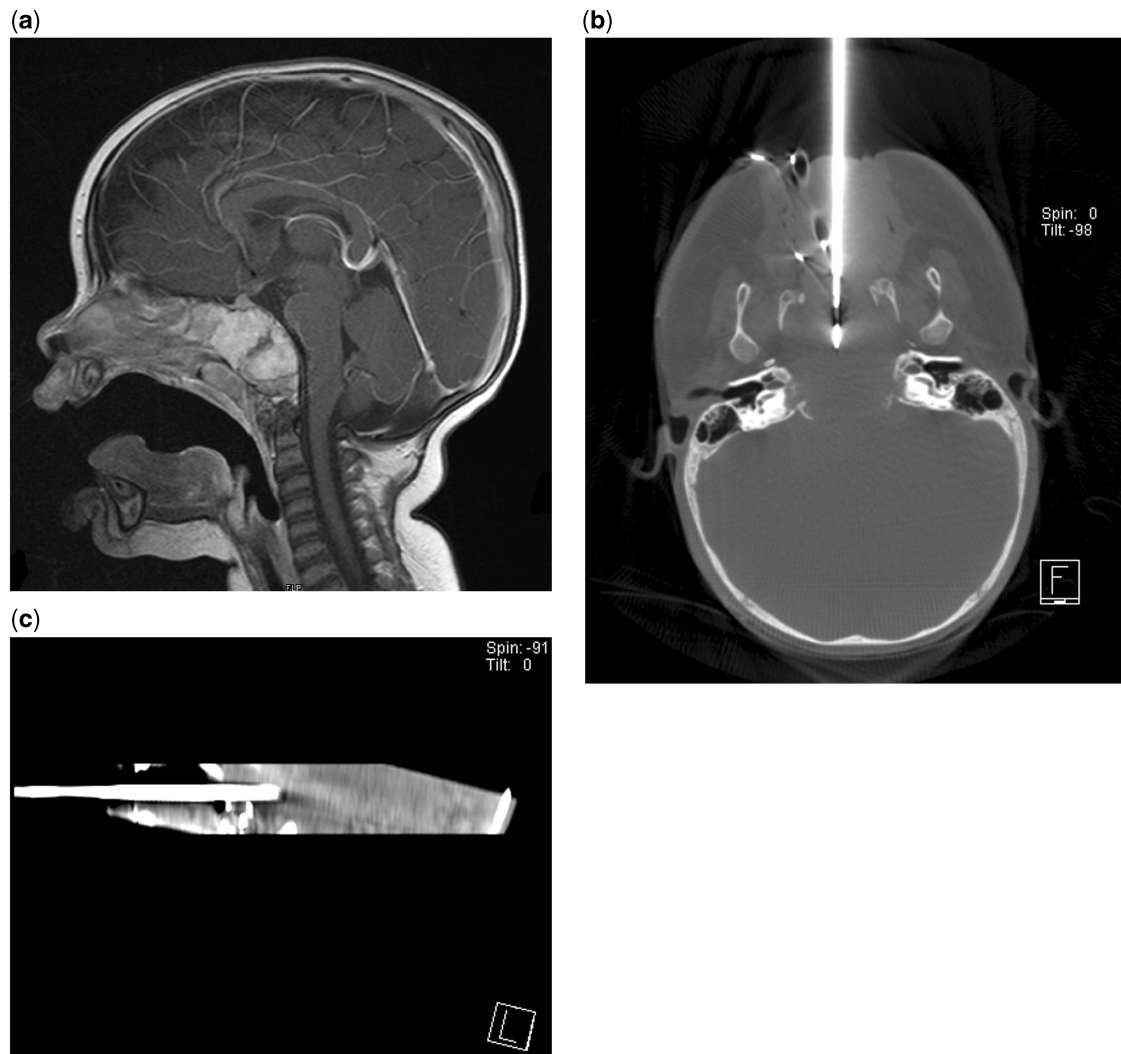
Needle biopsy using cone beam CT in an angiography suite. (a) Sagittal contrast-enhanced T1-weighted MR image of a 10-month-old boy shows an enhancing lesion in the clivus. (b) A 15/16-gauge coaxial needle is advanced through the mouth. (c) Multiplanar reconstructions are used to confirm the position of the needle during biopsy.
